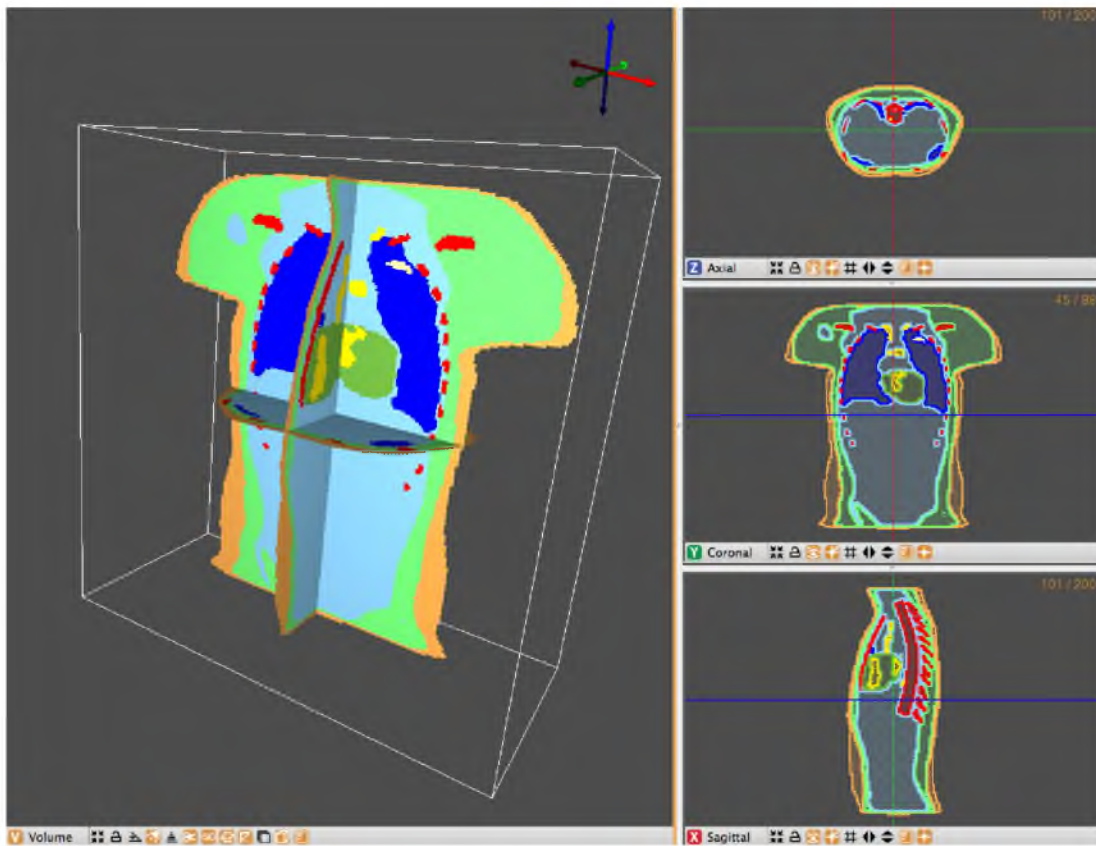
A segmented torso MRI scan produced by Seg3D. The figure shows the graphical display of Seg3D with a segmentation of a human torso in which every color represents a separate tissue type. The label maps are written to file as integer values representing each tissue.
